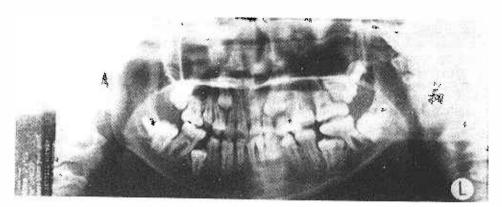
Case 1 — Pre-operative orthopantomogram showing ankylosis of left temporomandibular joint.
